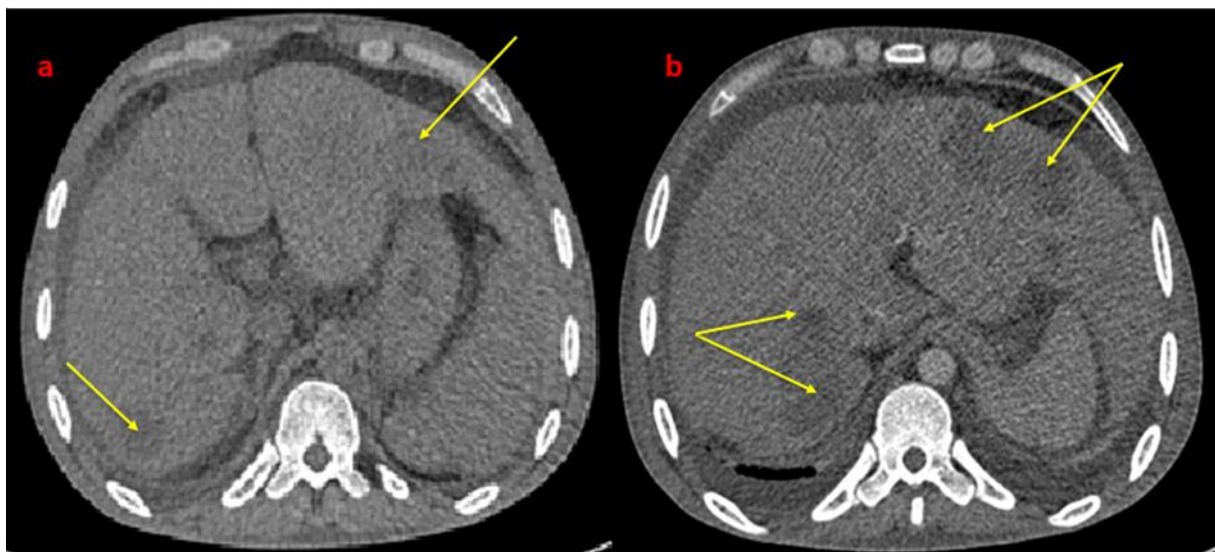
a: Non-contrast-enhanced abdominal CT scan shows multiples hypodense hepatic lesions. b: After the intravenous administration of iodinated contrast the lesion showing moderate enhancement in the portal-vein phase.
